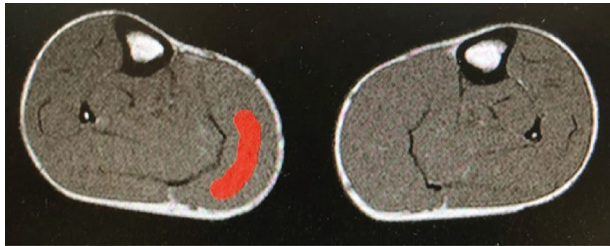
Example MRI of a patient's legs. The highlighted region in the gastrocnemius is the ROI used to calculate the texture parameters.
